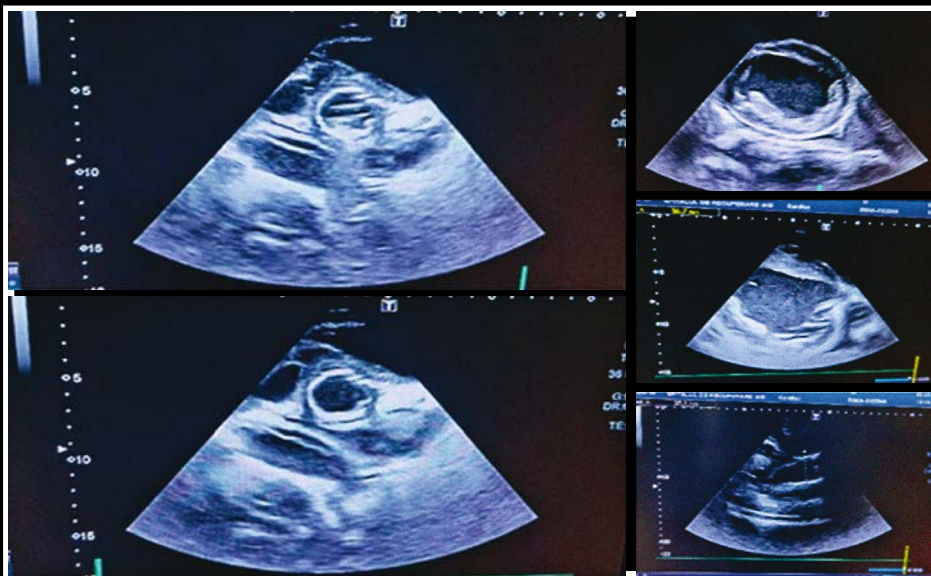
Patient's cardiac ultrasound
